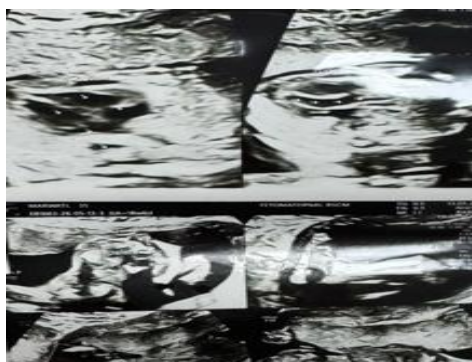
Initial ultrasonography performed at Primaya Hospital Bekasi Timur on April 20, 2026. (A) The smaller embryonic structure measured a crown-rump length of 1.66 cm, corresponding to approximately 8 weeks of gestation. (B) The larger fetus demonstrated biometric measurements corresponding to approximately 16 weeks of gestation, with an estimated fetal weight of 166 g. (C) Cardiac activity of the larger fetus was recorded at 148 beats per minute.
